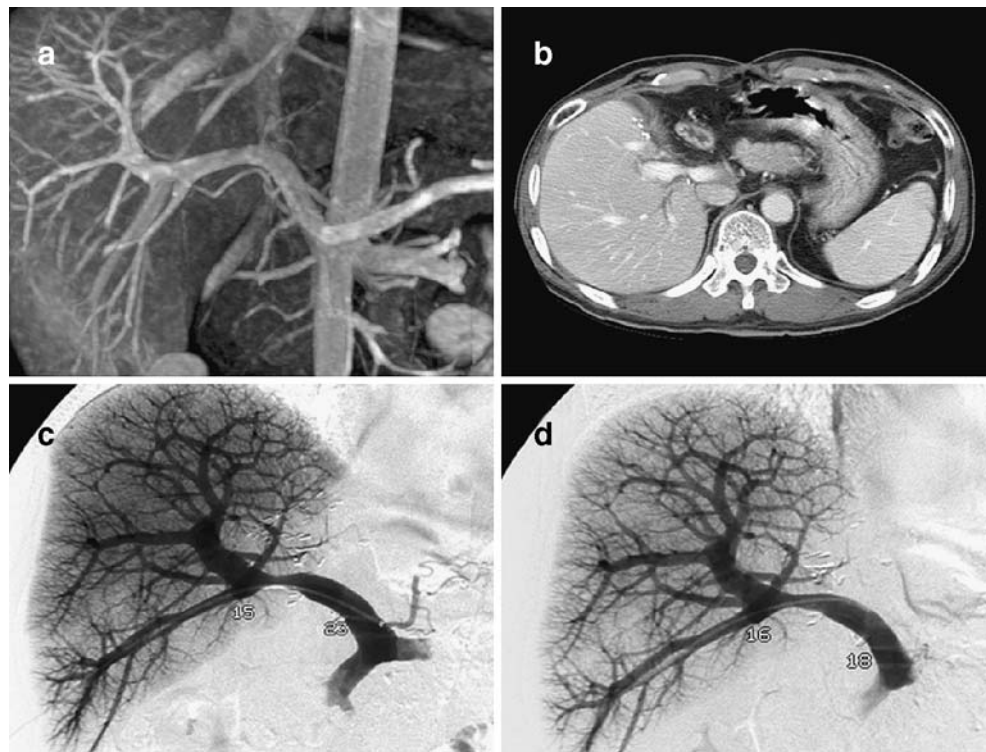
Imaging studies of the case 2. a Preoperative magnetic resonance imaging showing encasement of PV bifurcation. A 4-cm-long PV segment was resected due to heavy adhesion and direct infiltration by the tumor. b At 4 months after surgery, a waist was detected at the proximal anastomosis of PV. c After 6 months, percutaneous balloon dilatation was attempted. There was a pressure gradient of 8 mm H₂O across the PV wasting. d After balloon dilatation, the pressure gradient was reduced to 2 mm H₂O.
